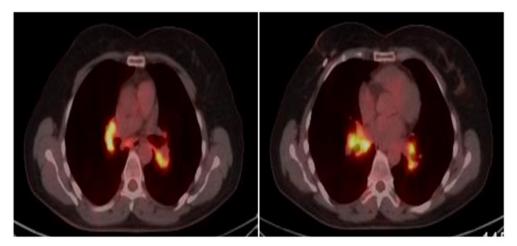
Case 1 PET-CT Sections.
